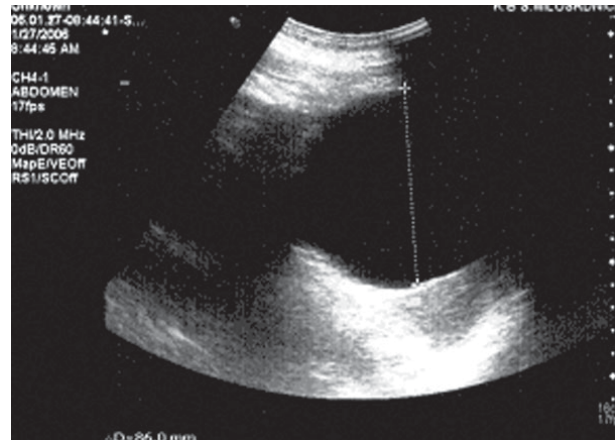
Ultrasound scan showing a pancreatic pseudocyst, 86 mm in diameter (ten days before drainage).
